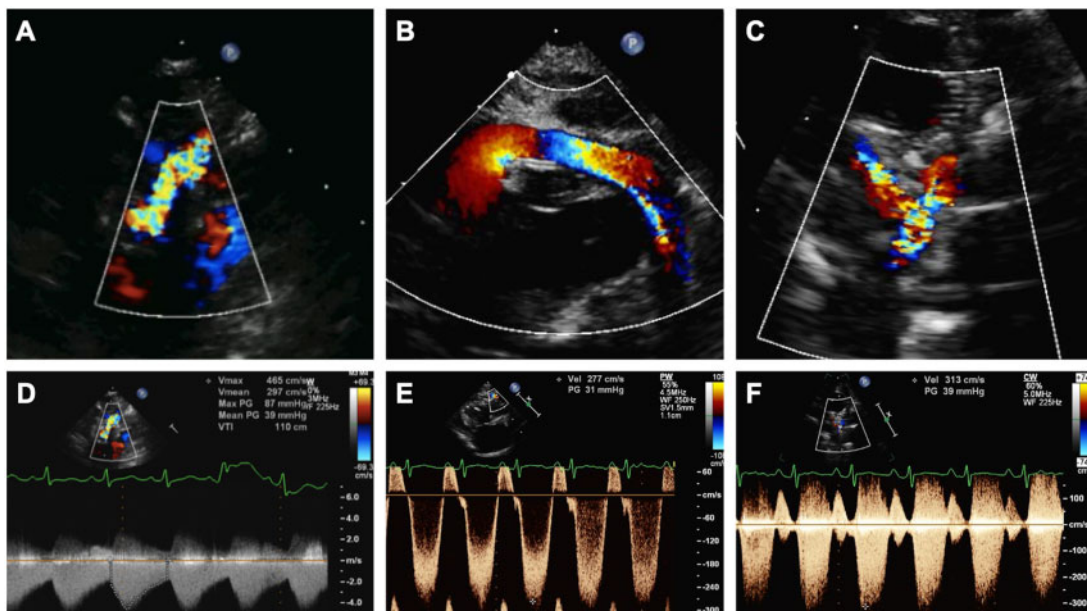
Post-Norwood echocardiography (A-F). Modified Blalock-Taussig shunt flow (A) and Doppler scan (D); proximal right ventricle-pulmonary artery conduit (B) and Doppler scan (E); distal right ventricle-pulmonary artery conduit and branch pulmonary arteries (C) and Doppler scan (F).
